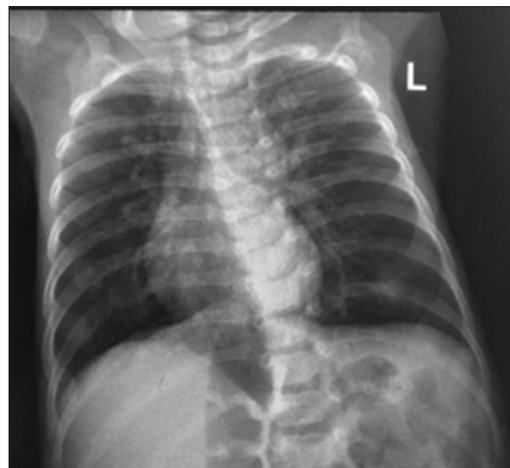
Chest Xray of case 1 showing hyperinflation.
